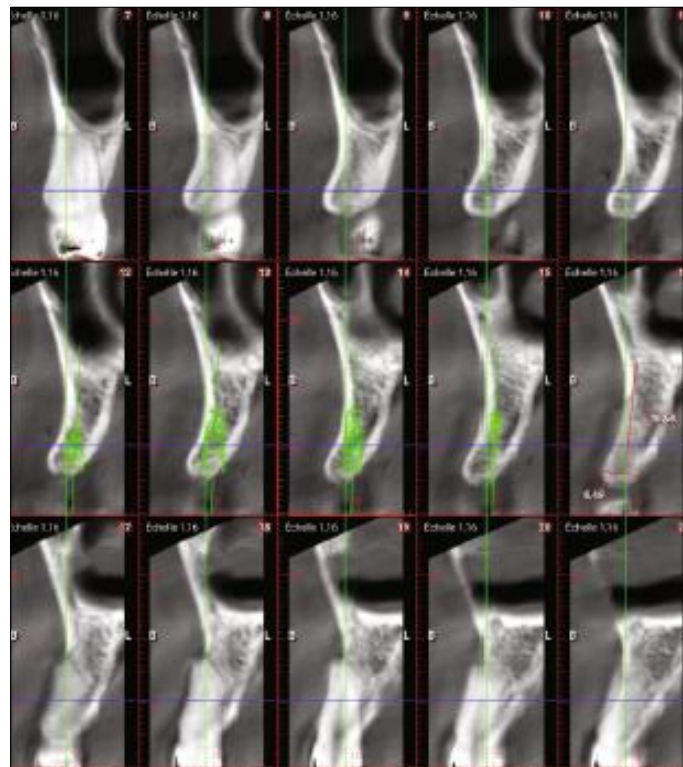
Sagittal cone-beam computed tomography (CBCT) cross-sectional image of the lateral incisor region demonstrating limited residual alveolar ridge width
